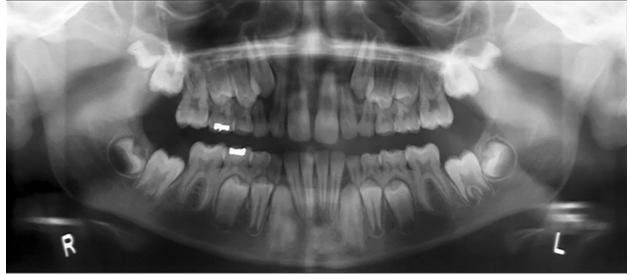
Panoramic radiograph of a mixed dentition.
